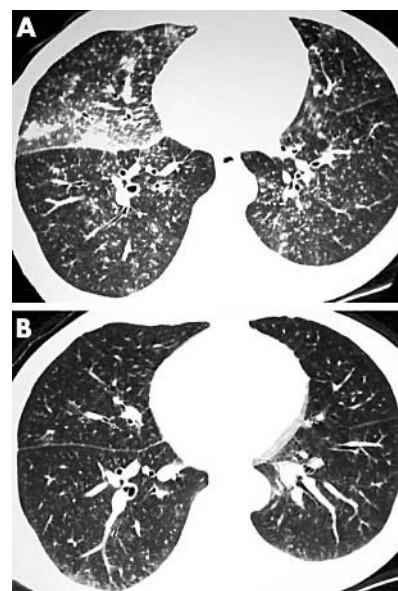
(A) High resolution computed tomography (HRCT) scan of the chest showing diffuse random nodules with mild septal thickening and right lower lobe consolidation. (B) HRCT scan of the chest after 3 months of HAART demonstrating marked improvement in nodules, septal thickening, and consolidation. Note: The images are from comparable but not identical levels of the lung.
